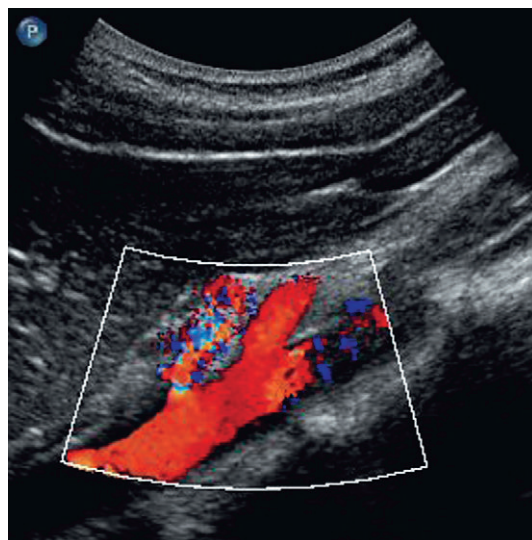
Longitudinal scan showing the origin of the coeliac axis superiorly and the superior mesenteric artery just below this. Colour Doppler shows aliasing and a tissue bruit around a stenotic coeliac axis origin.
